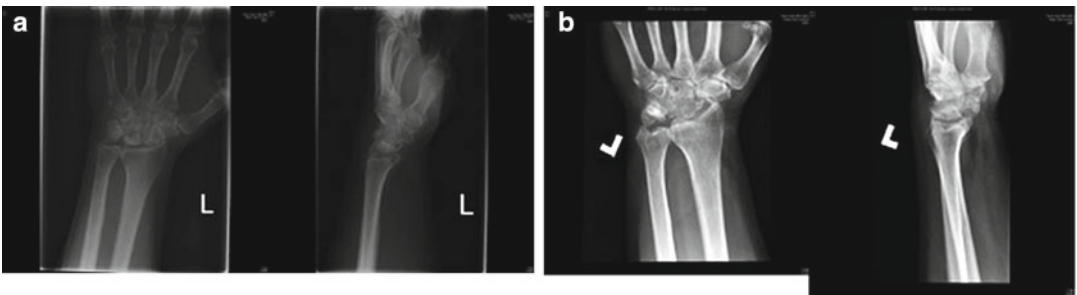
(a) Preoperative radiograph of 62-year-old man with stage 3B disease. (b) Postoperative radiograph 3 years after proximal row carpectomy
